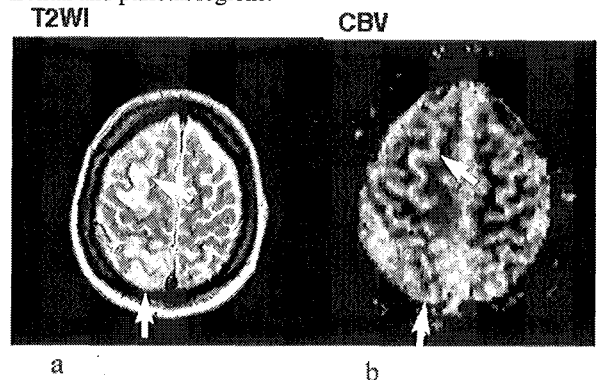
Ictal epilepsy. a. T2-weighted image shows hyperintensity lesions in frontal and parietal lobes (arrows). b. Relative rCBV map. Increased rCBV areas in right frontal and parietal lesions (arrows).
